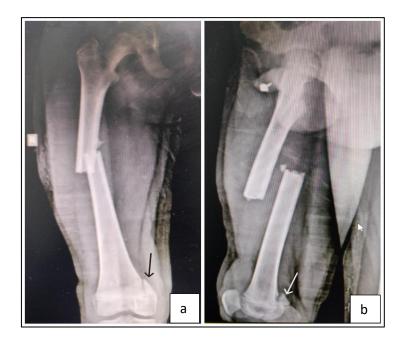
(a and b): Antero-posterior and lateral X-ray views of right thigh showing displaced mid diaphyseal fracture of right femur with Hoffa fracture of medial femoral condyle in Antero-posterior (black arrow) and lateral view (white arrow).
